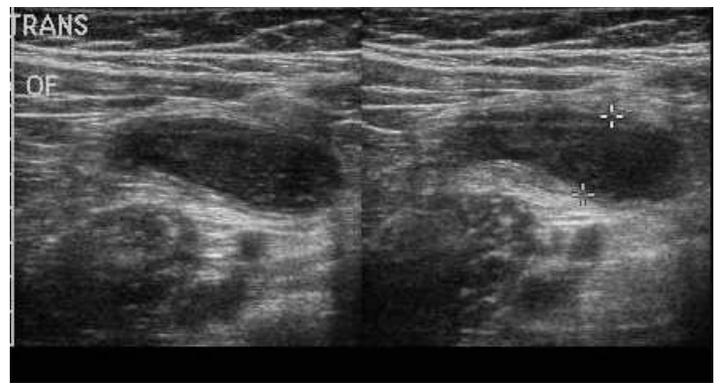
Ultrasound of a 2-year-old child showing a dilated tubular structure without change with compression.
